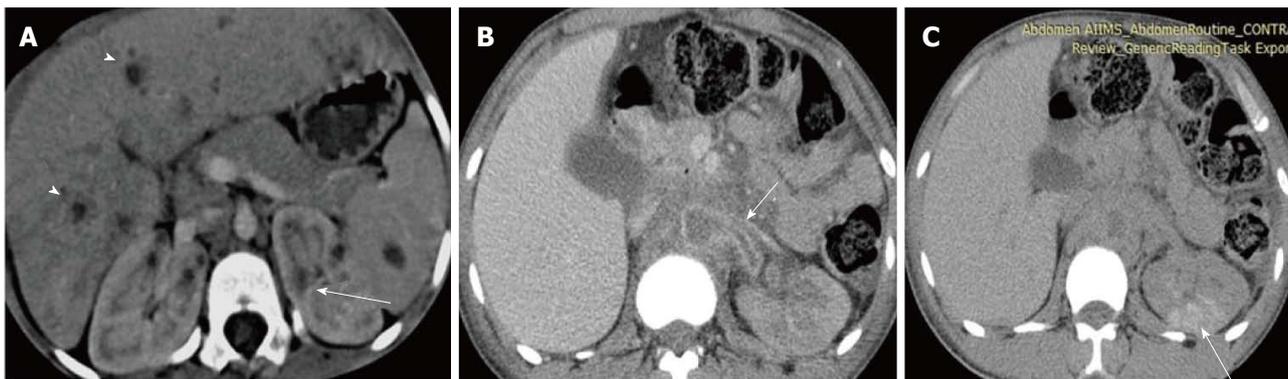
Fungal infection. A: CECT shows liver, spleen and bilateral kidneys studded with small hypodense lesions in a 10 years old leukemia patient who was proven to have *Aspergillus* infection on aspiration cytology. The patient also had lung involvement with contiguous cardiac thrombus (not shown); B, C: Nephrographic (B) and delayed (C) phase CECT in a 26 years old aplastic anemia patient reveal a poorly enhancing, non-excreting left kidney with perinephric inflammation. Aorta and left renal artery are almost completely occluded by a non-enhancing thrombus (arrow B). On delayed image (Figure C), patchy areas of enhancement (arrow) noted in left kidney are characteristic of acute pyelonephritis. FNAC from the perirenal soft tissue revealed fungal hyphae and diagnosis of angioinvasive fungal infection (*Mucor*) was made and Amphotericin B was started. However patient expired two days later. CECT: Contrast-enhanced computed tomography.
